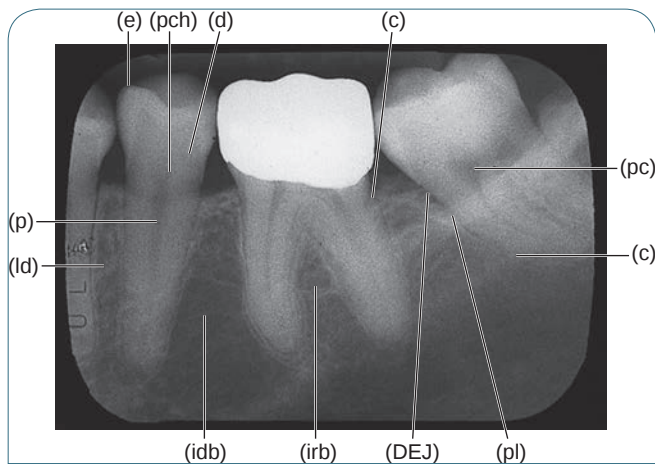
X-rays identifying the parts of a tooth and surrounding structures: (d) Dentin. (c) Cementum. (e) Enamel. (p) Pulp canal. (pch) Pulp chamber. (DEJ) Dentinoenamel junction. (pl) Periodontal ligament (black line). (ld) Lamina dura (white area of cortical bone). (irb) Interradicular bone. (idb) Interdental bone.
